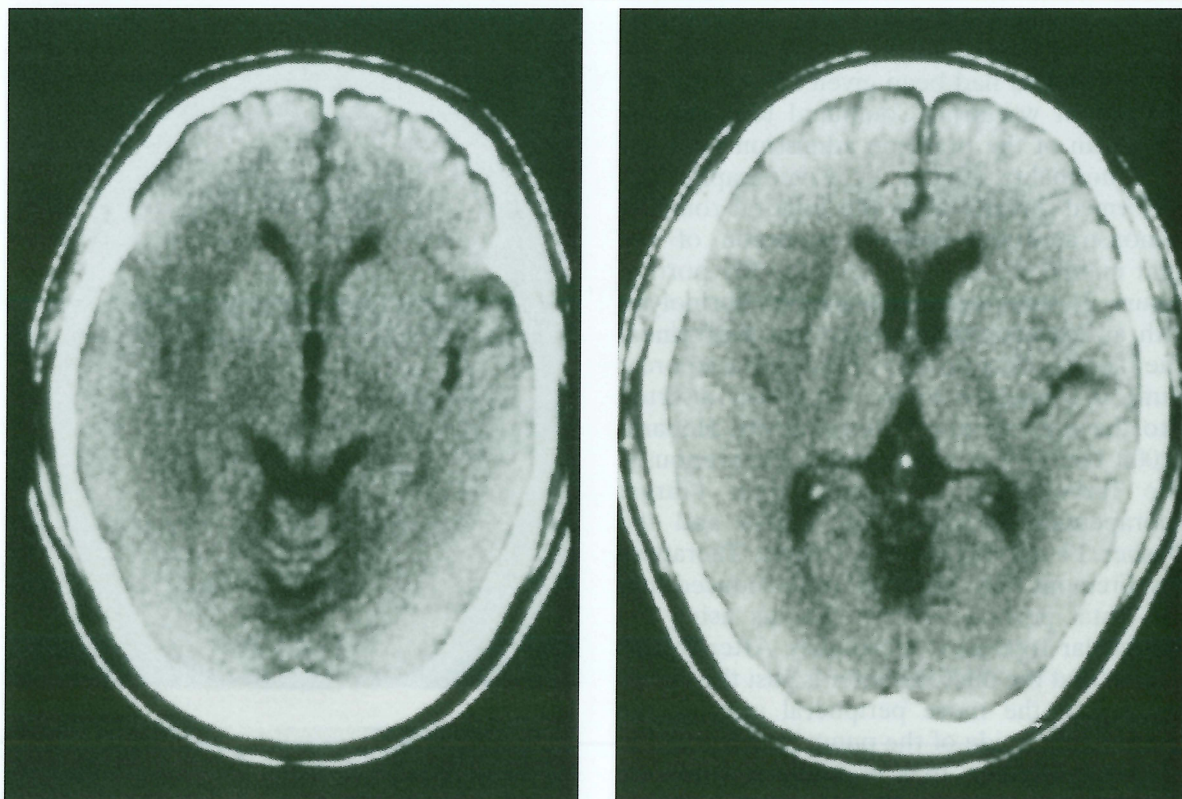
Computed tomography at one week after treatment, showing a small low-density spot in the territory of the middle cerebral artery.
